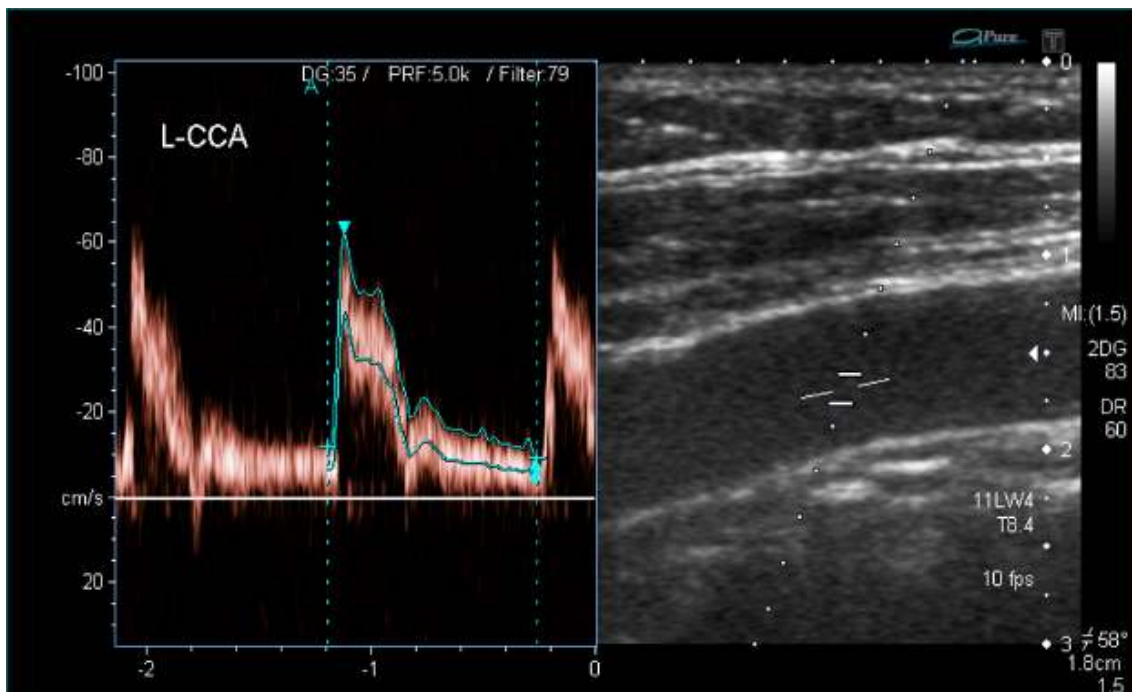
A 50 year old male who had history of TIA underwent ultrasound carotid Doppler and had no plaque
